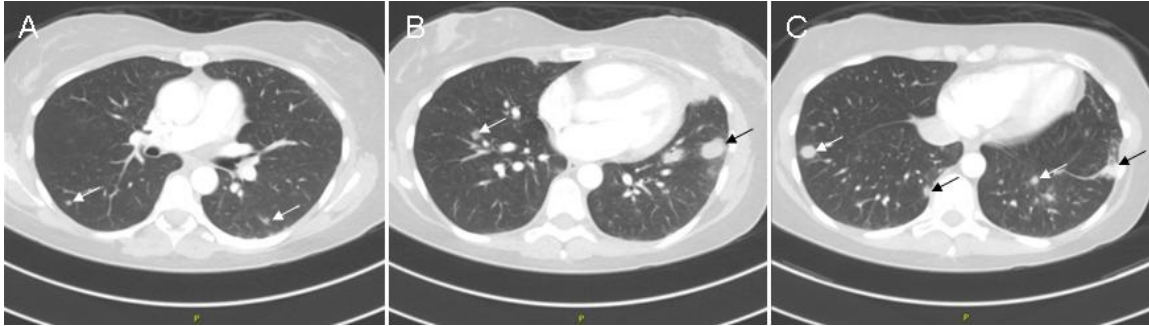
Thoracic CT scan lung windows from figure 1 showing multiple lung nodules (arrows). The mediastinal windows do not show any mediastinal lymphadenopathy.
